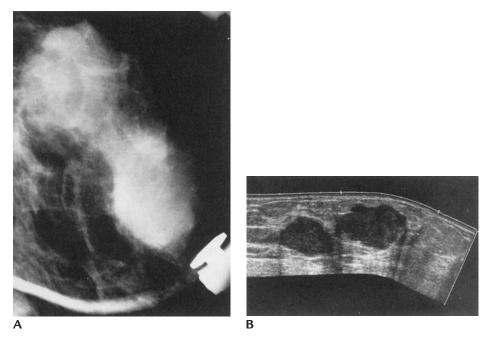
Metastatic small cell lung carcinoma. (A) Spot compression view. Two, round, masses with indistinct margins. (B) Round masses with lobulated margins and slight posterior acoustic enhancement. Margins better defined on ultrasound.
